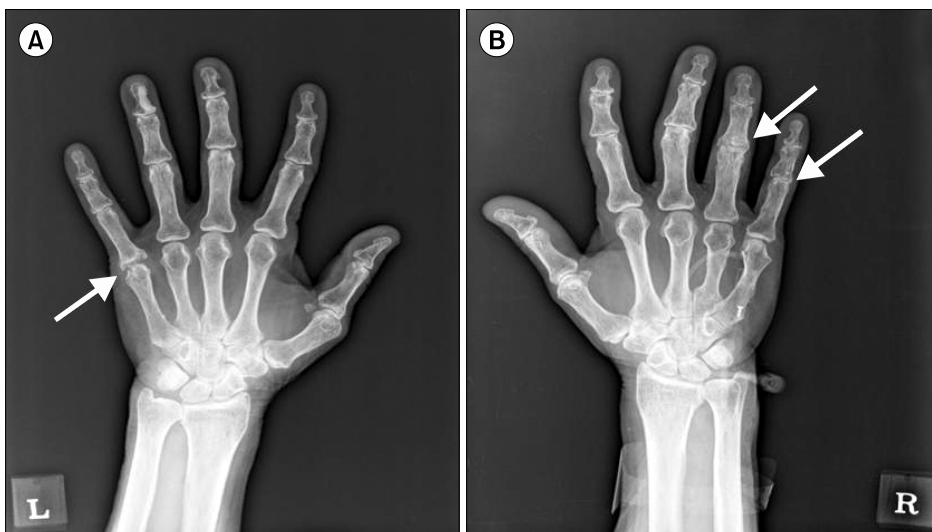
Plain radiographs of both hands showed a marginal bone erosion in the left 5th metacarpophalangeal joint (A; white arrow) and joint space narrowing with marginal bone erosion in the right 4th and 5th proximal interphalangeal joints (B; white arrows).
